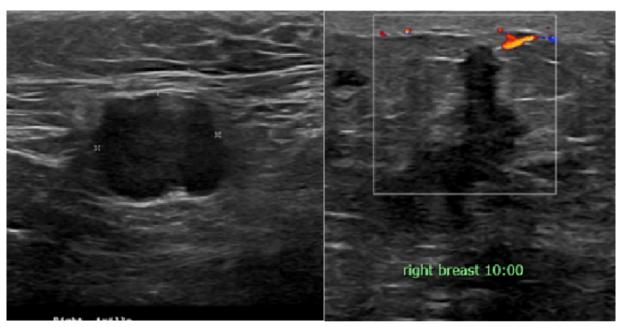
Breast ultrasound done 4 months later. Image 2a shows a diffuse increase in the thickening of an axillary lymph node which is round with irregular borders and loss of fatty hilum. Image 2b shows irregular hypoechoic mass with indistinct borders and surrounding echogenic halo. There is diffuse skin thickening and edema of the breast tissue.
